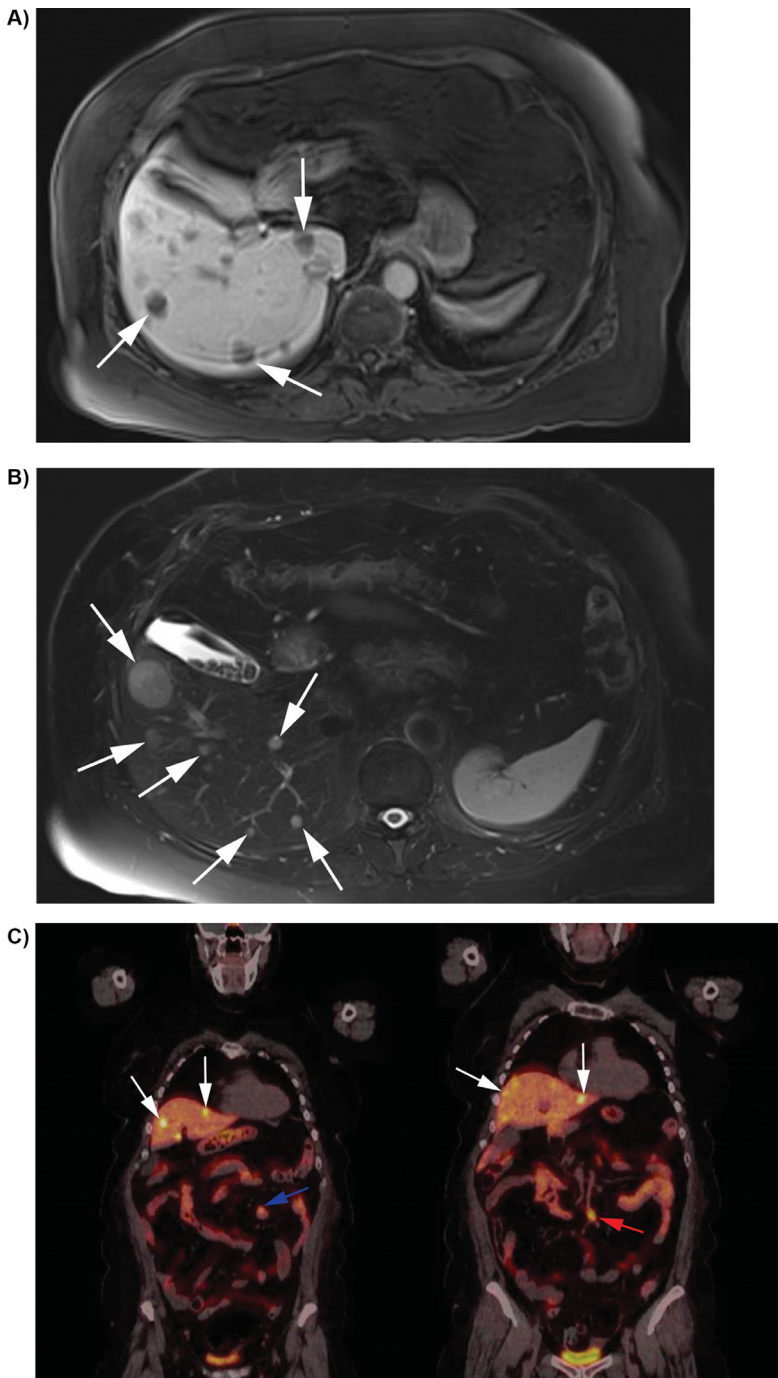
Axial MRI of hepatic metastases (arrows) from an SBNET in the same patient shown in Fig. 6. Metastases appear hypointense on T1-weighted MRI (A) and hyperintense on T2-weighted MRI (B). C) ^{68}Ga -DOTATATE scan showing primary SBNET (blue arrow), nodal metastasis (red arrow), and liver metastases (white arrows) in the same patient.
